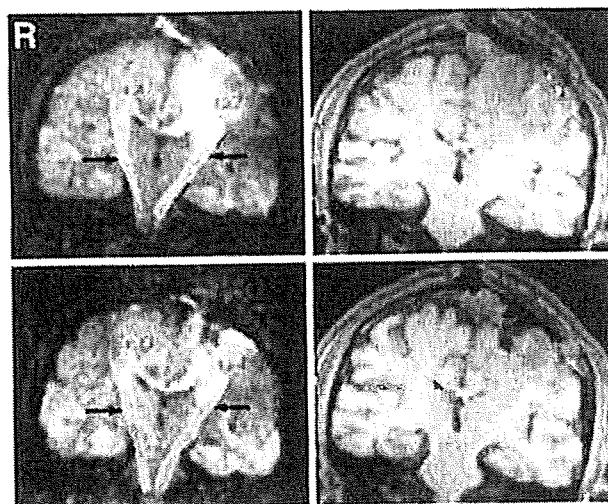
Coronal intraoperative diffusion-weighted (left column) and T_1 -weighted magnetic resonance images (right column) before (upper row) and after resection of the frontal lobe glioblastoma (lower row). The white matter bundle containing the pyramidal tract was shifted laterally by the superomedial tumor, whereas removal of the neoplasm was accompanied by its inward displacement (maximum 2.7 mm). The maximum displacement was measured between the medial position of the tract contour (arrows) segmented manually on the diffusion-weighted images before and after resection, in the direction vertical to the craniocaudal axis from the vertex to the center of the mid-brain. Note that T_1 -weighted images demonstrate only hypointense tumor and resection cavity, but not the pyramidal tract.
